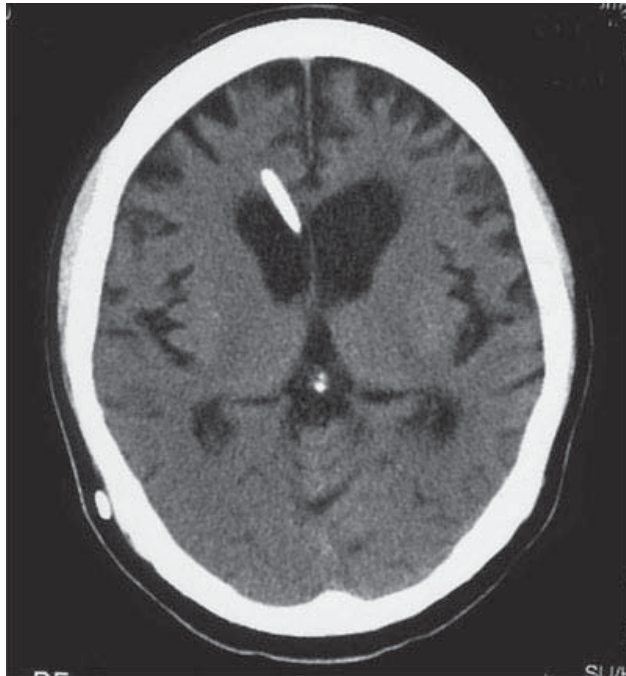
CT scan 1 week after implantation shows that there are no complications such as bleeding.
